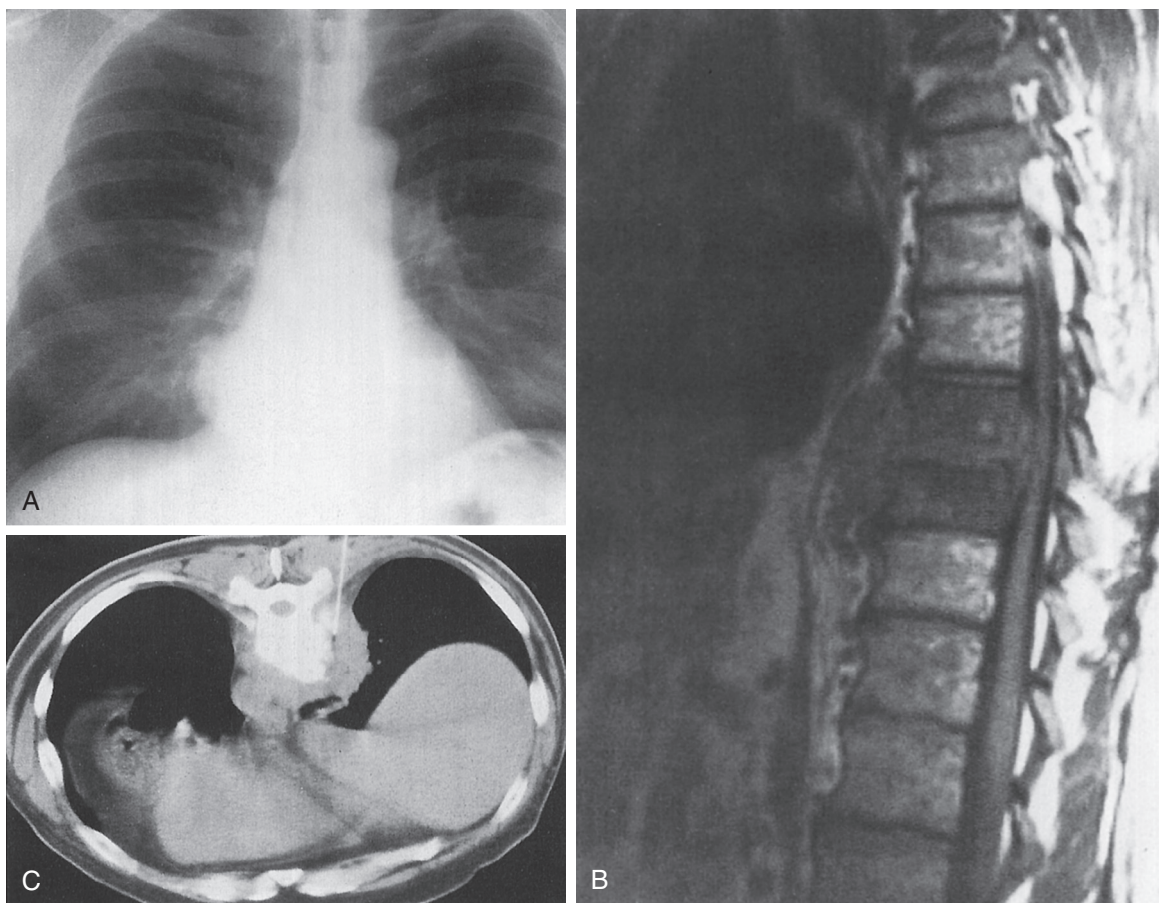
■ Paraspinous abscess in a 45-year-old man with AIDS and a systemic infection. A, Frontal chest radiograph demonstrates a mass behind the right side of the heart. B, Spinal MRI demonstrates reduced intensity in two vertebral bodies with posterior and anterior masses. C, CT-guided aspiration of the mass demonstrated a paraspinous *Staphylococcus aureus* infection. (Reprinted with permission from Gamsu G: The mediastinum. In Moss AA, Gamsu G, Genant HK, editors: *Computed tomography of the body*, ed 2, vol 1, Philadelphia, 1992, WB Saunders, p 83.)
